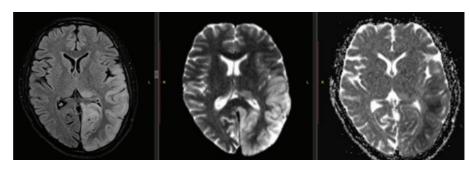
MRI of the brain of patient N. dated 04/05/2019 with signs of cerebral hyperperfusion with damage to the left occipital, parietal lobe, and thalamic cushion on the left
